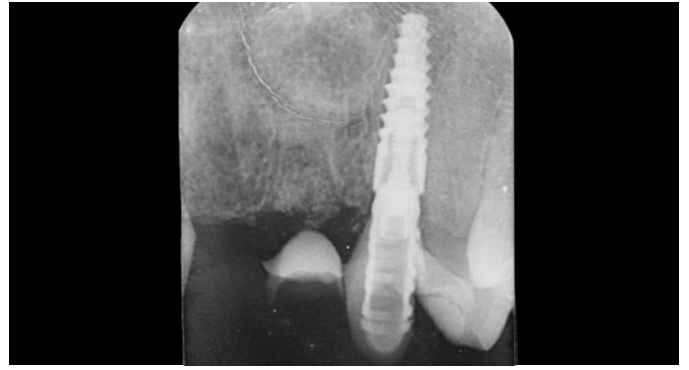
Post-operative radiograph of implant at the UL3 site
